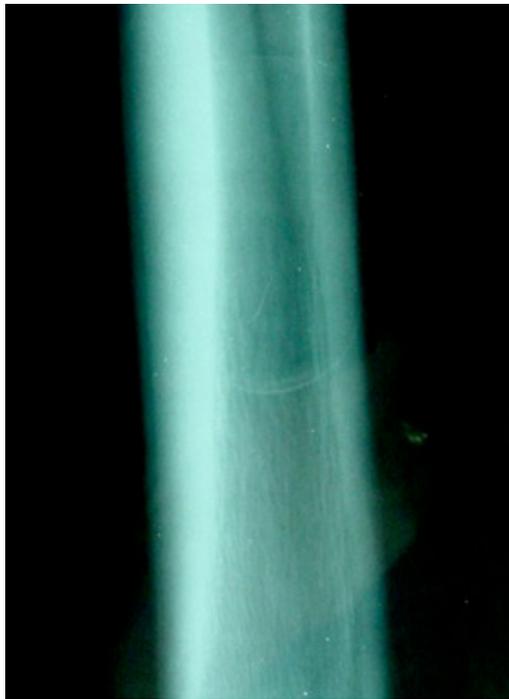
DMPLO of the dorsolateral cortex of MCIII in Case 1 with dorsal cortical stress fracture. Radiograph was taken 10 weeks post-shockwave therapy showing intact cortex and no signs of previous stress fracture.
